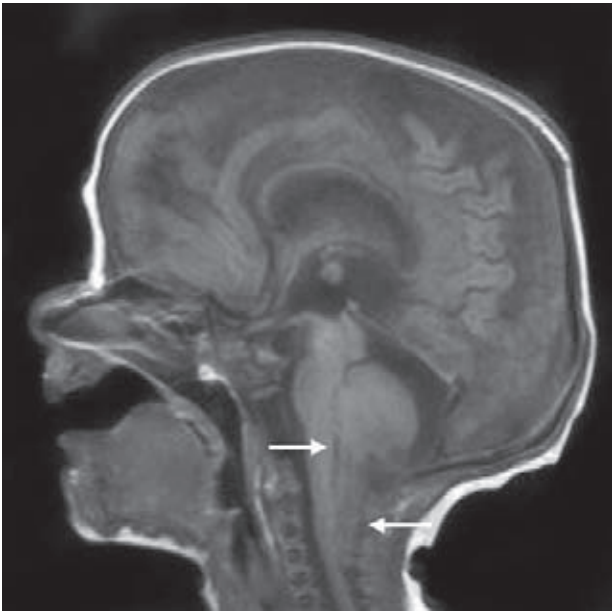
Chiari II malformation. Sagittal T1-weighted MR image shows a small posterior cranial fossa and inferior displacement of the cerebellum through the foramen magnum (white arrow). The fourth ventricle is narrow and displaced caudally (white arrow)
